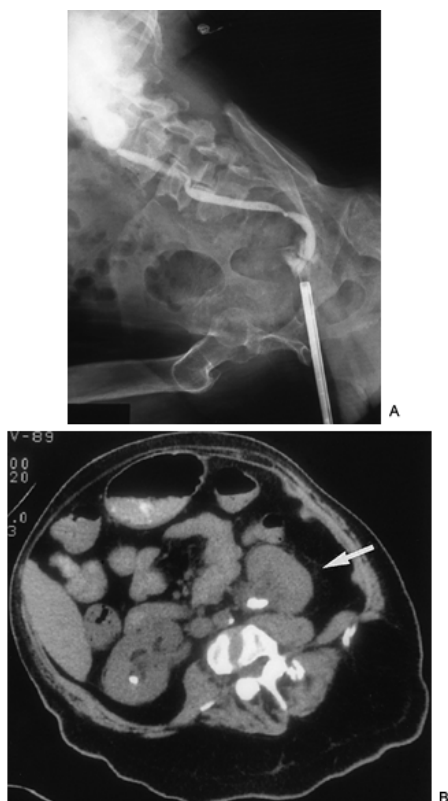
A: Retrograde study reveals renal pelvic stones that are difficult to see because they overlie the spine in this patient with severe body contractures. B: Computed tomography scan without contrast shows bilateral renal pelvic calculi and suggests an appropriate “window” (*arrow*) for safe percutaneous access.
